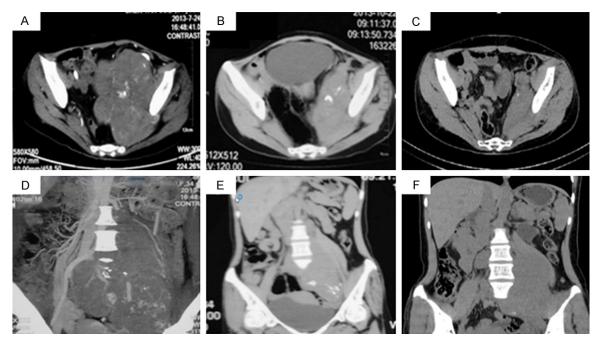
The follow-up CT scan (A) and (D) were taken on July 24th 2013; (B) and (E) were taken on October 22th 2013; (C) and (F) were taken on January 6th 2015.
